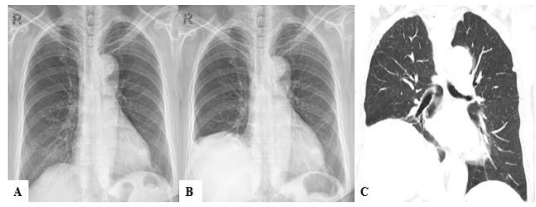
Chest radiograph (A) before and (B) after COVID-19 infection. (C) Chest computed tomography showed the elevation of the right diaphragm
